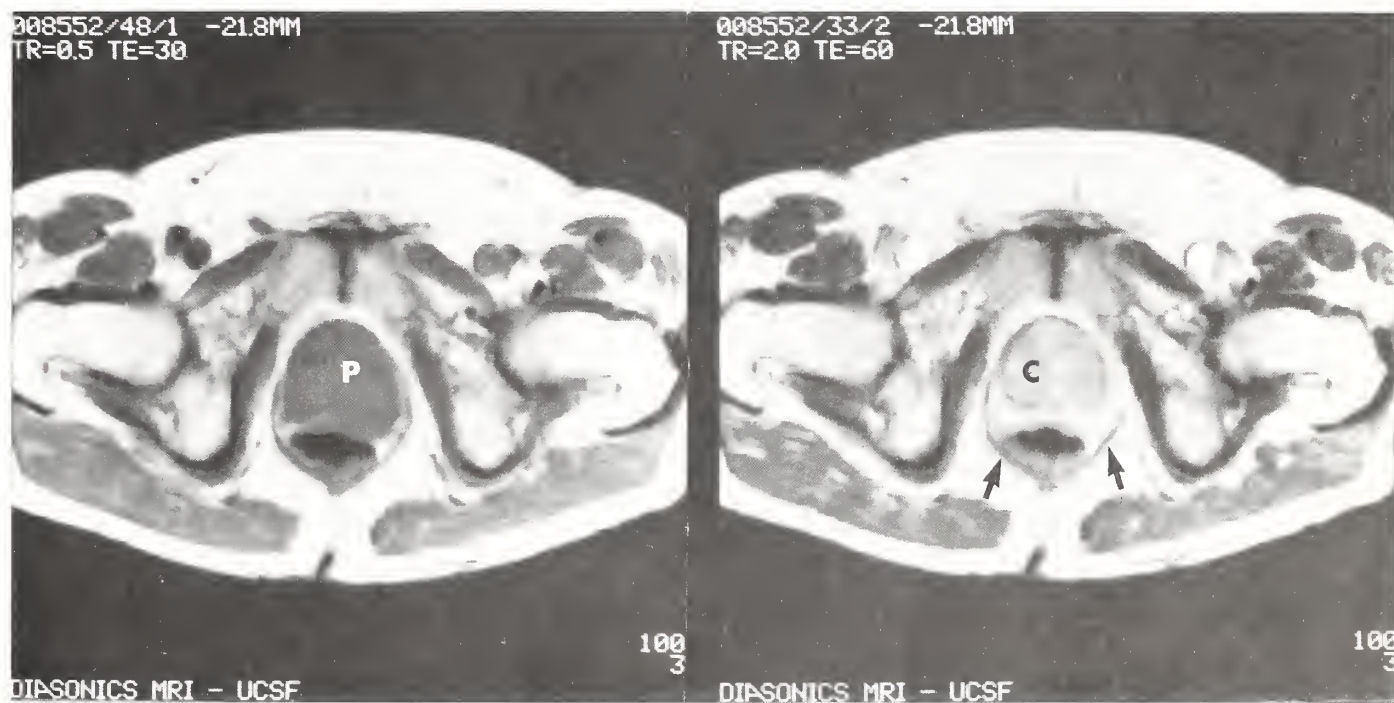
Stage B2 prostate carcinoma. *Left*: T1-weighted image (spin echo) SE 500/30. *Right*: T2-weighted image SE 2,000/60. Prostate (P) is enlarged. On T1-weighted image, contrast is excellent between prostate parenchyma and surrounding periprostatic tissue. No tumor spread outside the prostate is identified. On T2-weighted image, central gland of the prostate (C) is of low signal intensity and can be differentiated from higher signal intensity peripheral zone. Levator ani muscles (arrows) are clearly visualized and are of normal signal intensity.
